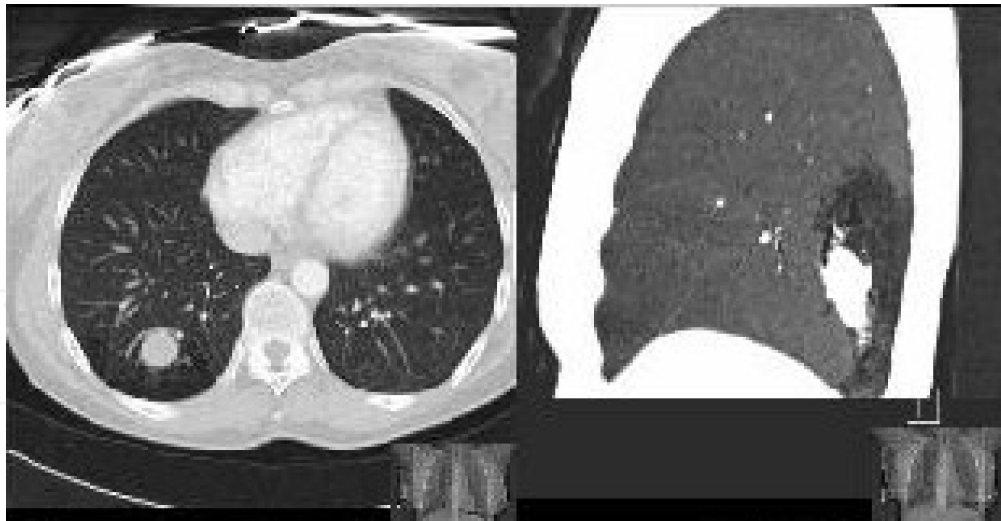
Polilobulated round mass located in the posterobasilar right subsegmental bronchi with a distal segmental area of radiolucency and lack of communication between the mucocoele and hilum on high-resolution computed tomography (Sacristán Bou et al., 2010).
